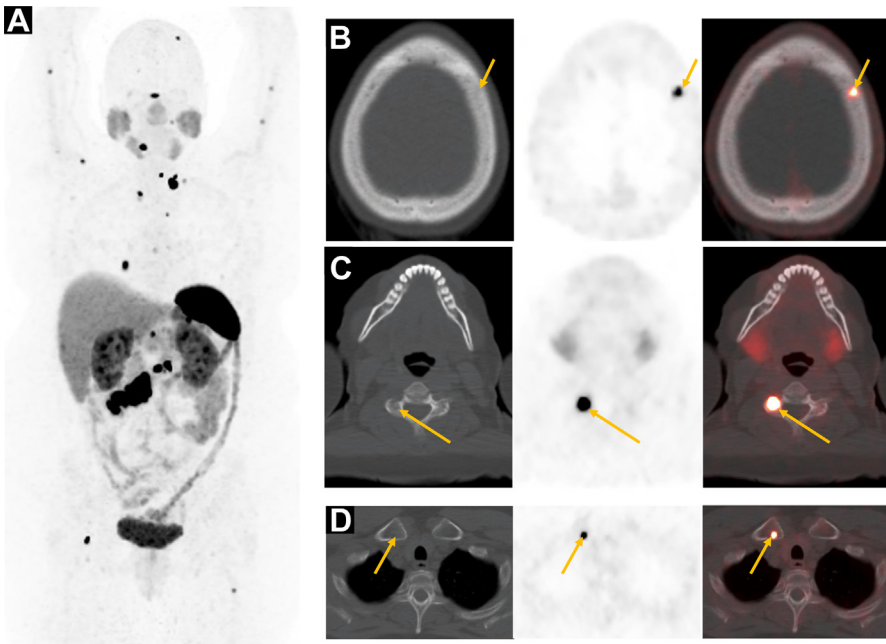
Initial staging of patient with G1 small bowel NET (Ki-67 < 3%). ^{64}Cu -DOTATATE PET-CT MIP image (A) shows diffuse osseous metastases. Transaxial images (B–D) show most osseous metastases to be occult on CT (arrows).
